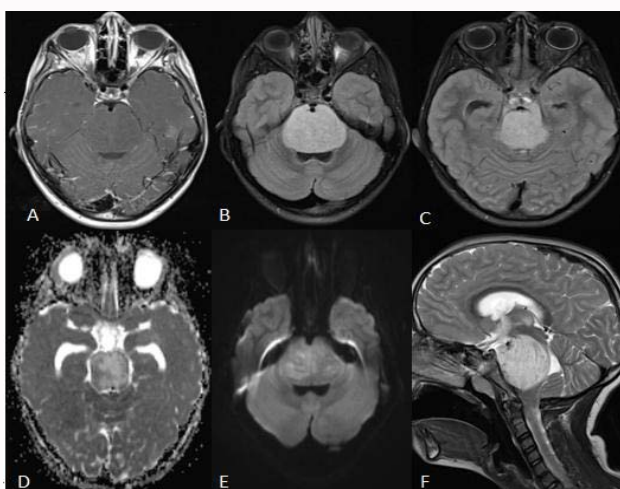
Intra-axial ponto-mesencephalic lesion, hypo/isointense in T1 (A), hyper intense in T2 and FLAIR (B,C), with foci of restriction to diffusion (D,E). The basilar artery is almost completely encased by the tumor, as it ascends in the interpeduncular fossa. There is marked compression of both the aqueduct and 4th ventricle, with subsequent supratentorial ventricular dilatation.
